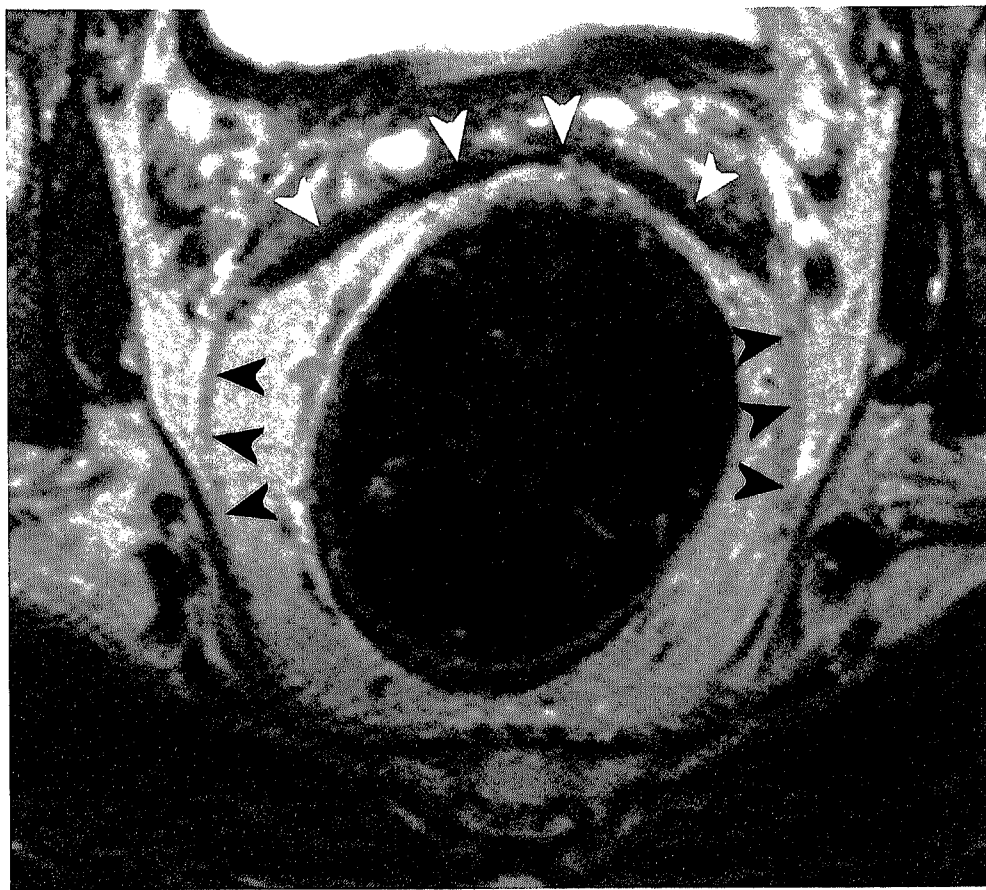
Axial T2W FSE (TR/TE 5312/150 msec) MR image of a healthy male volunteer shows the mesorectal fascia (black arrowheads) as a fine line of low signal intensity surrounding the mesorectal fat. The Denonvillier's fascia is also visualized (white arrowheads) posterior to the seminal vesicles.
